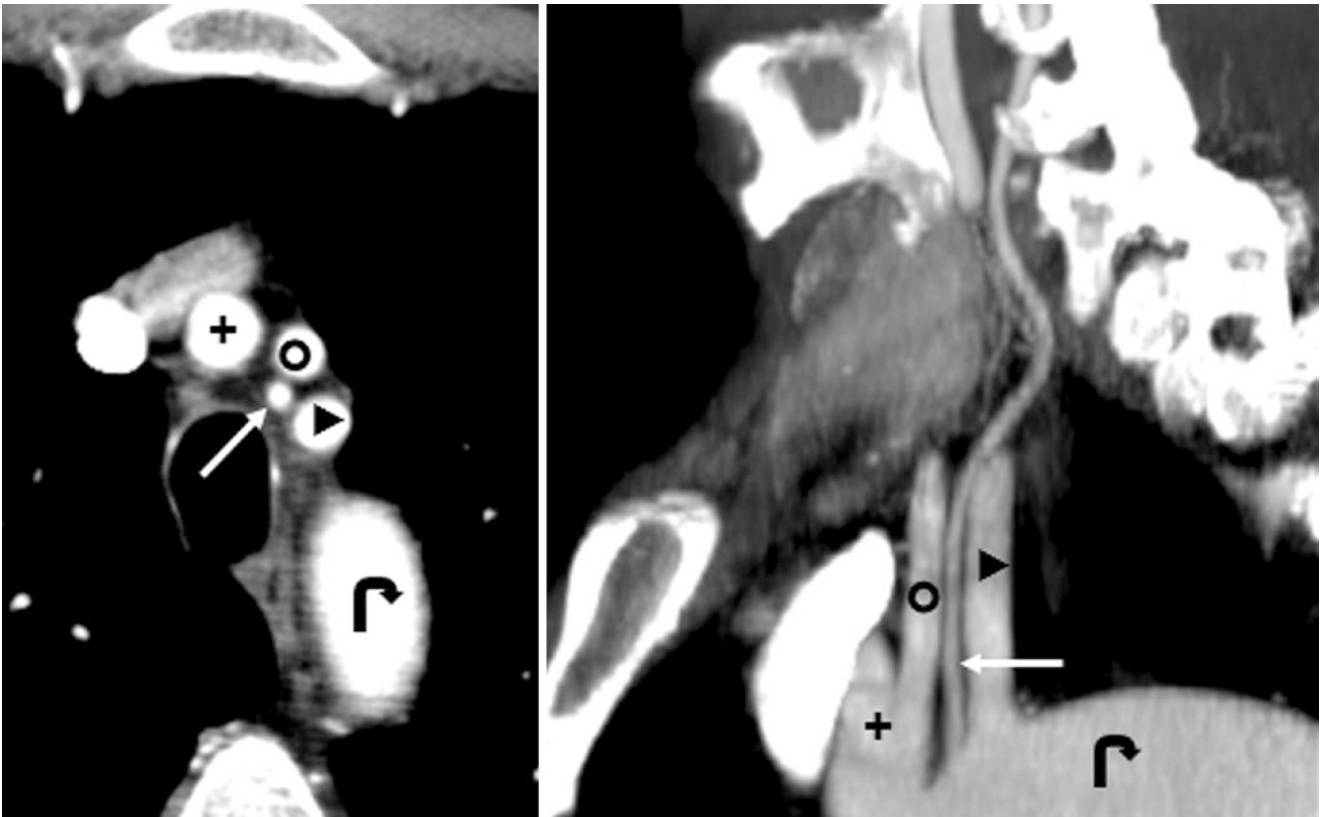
42-year-old with a LVA “arch origin” (arrows) on a CTA axial view (left) and 15-mm MPR coronal LAO view (right). The LVA lies between the LCCA and the left subclavian artery (LSCLA, right-facing arrowhead). Aortic Arch (curved arrows); IA Innominate Artery
